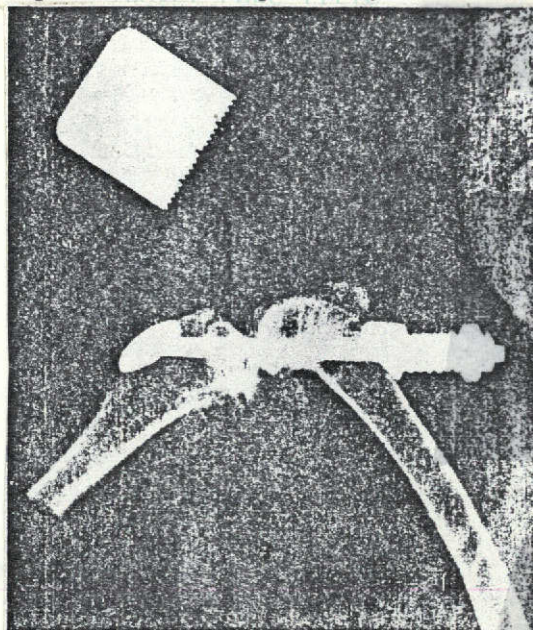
X-ray Picture, Later to the End of the Intervention With Simultaneously Superimposed Scale to Check Spring Compression.
